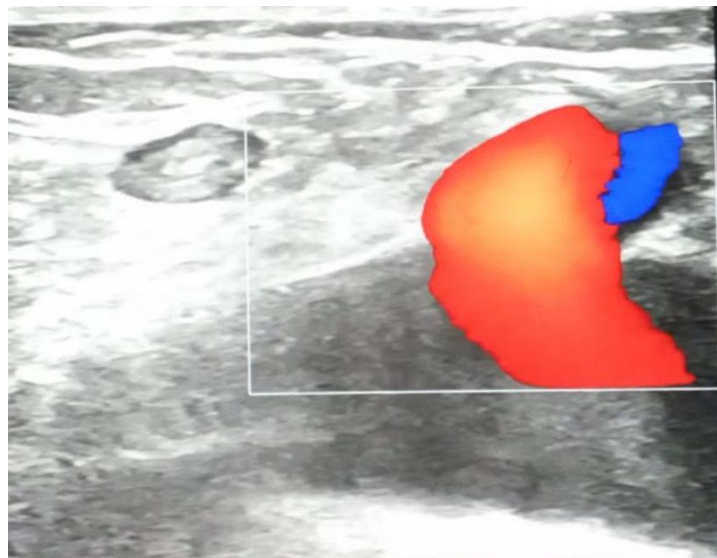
Duplex doppler USG showing reflux at SFJ
